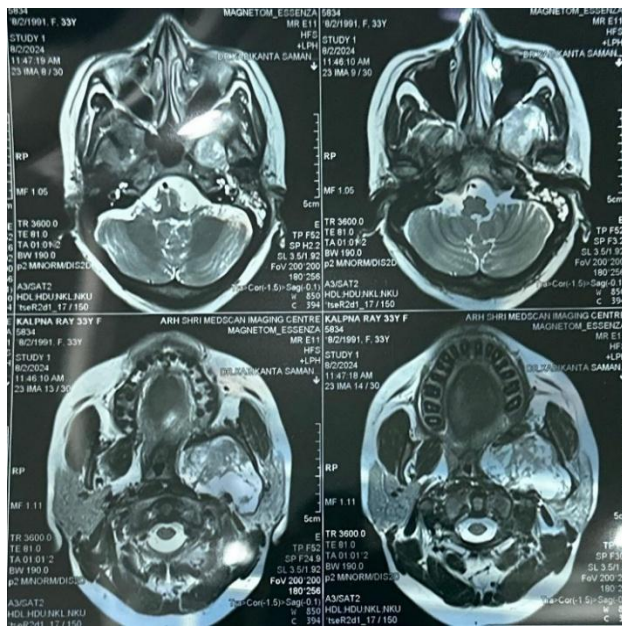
MRI neck and brain showing heterogenous contrast enhancement in region of Meckels cave posteriorly extending to CP angle cistern in the course of left trigeminal nerve abutting and displacing pons. Laterally, extending into floor of middle cranial fossa, Inferiorly, extending to left parapharyngeal space through foramen ovale, Medially, the lesion extended into cavernous sinus encasing cavernosal segment of left ICA over ~120 degree.
